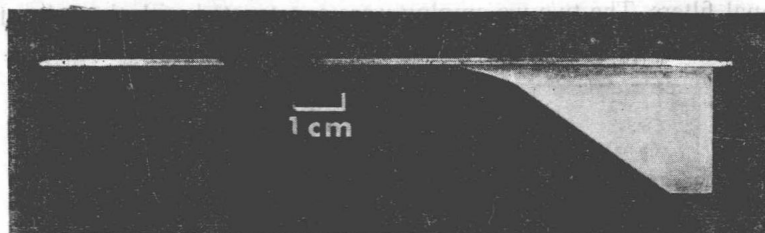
The shape of the wedge filter used for lateral views of the uterus, viewed from the side (the x-ray beam is vertical). The aluminium helps prevent over-exposure of anterior part of the uterus, and reduces fetal x-ray dose
